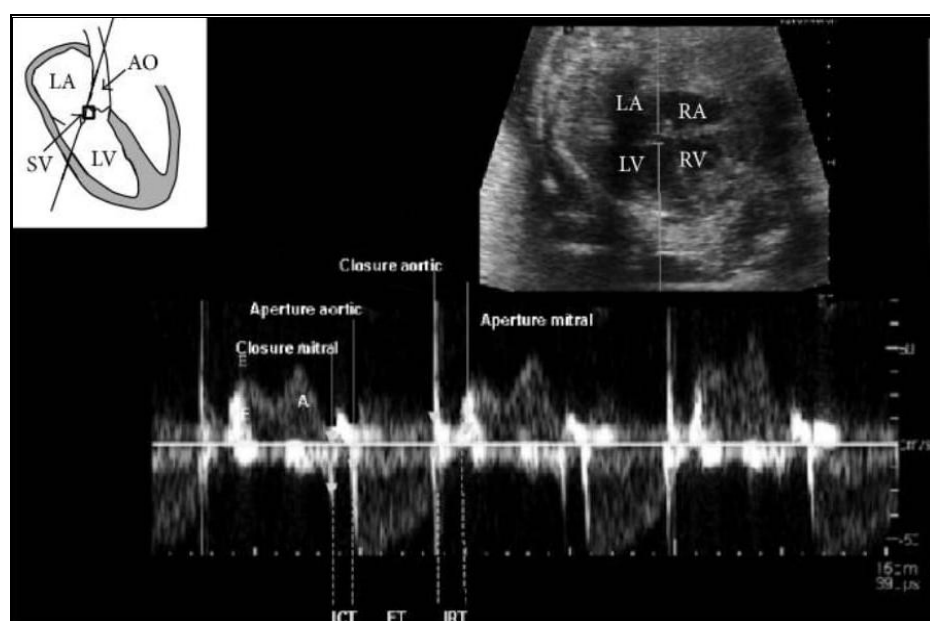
Doppler assessment of the left myocardial performance index. The sample volume is located over the lateral wall of the aorta, close to the mitral valve. References for the time-period estimations are based on the echoes from the mitral and aortic valve movements. The E/A waveform is always displayed as positive flow. ET, ejection time; ICT, isovolumetric contraction time; IRT, isovolumetric relaxation time (9).
